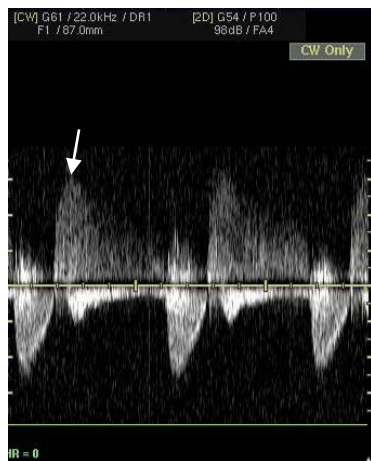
Research from apex position: doppler echocardiography (continuous wave Doppler). Aortic regurgitation (arrow). Aortic insufficiency
